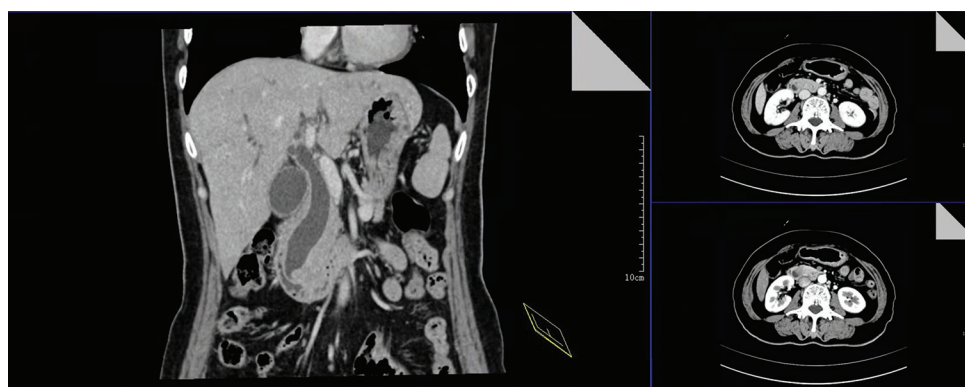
Abdominal computed tomography shows dilated intra- and extra-hepatic bile ducts, a dilated pancreatic duct, and an ampullary mass
